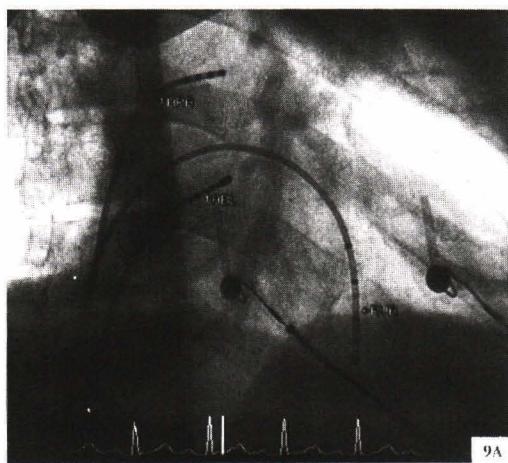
X-rays of the successful spot in AVNRT (A) Right anterior oblique view (RAO) (B) Left anterior oblique view (LAO).
